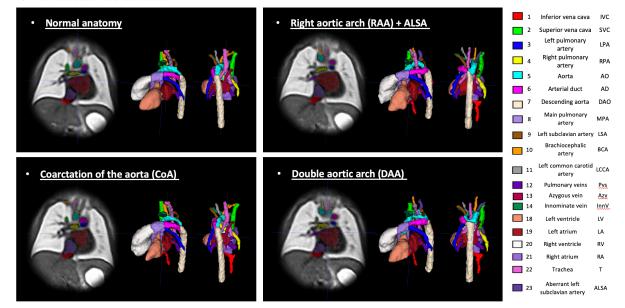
Generated 3D T2w black blood atlases of the normal fetal heart and aortic arch anomalies together with the 3D segmentations of the main 19 cardiovascular structures. The atlases are available at SVRTK fetal MRI data repository [12].
